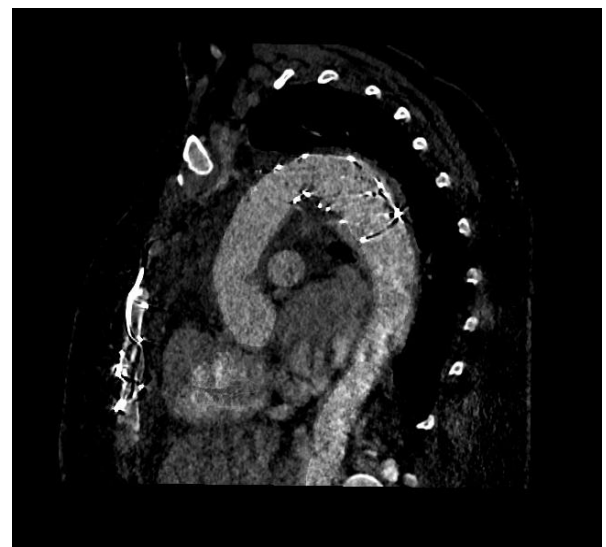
Postoperative computed tomographic scan, sagittal view, (with contrast agent), showing the good result of the procedure of the hybrid prosthesis
